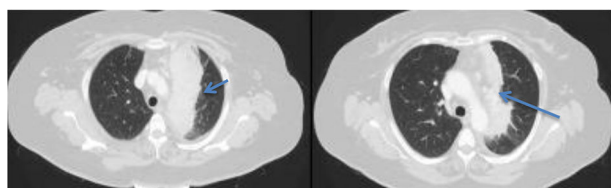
CT scan at the beginning of the lung mass study in case 2. A mass can be seen in the LUL and mediastinal adenopathies next to the aortic arch.
